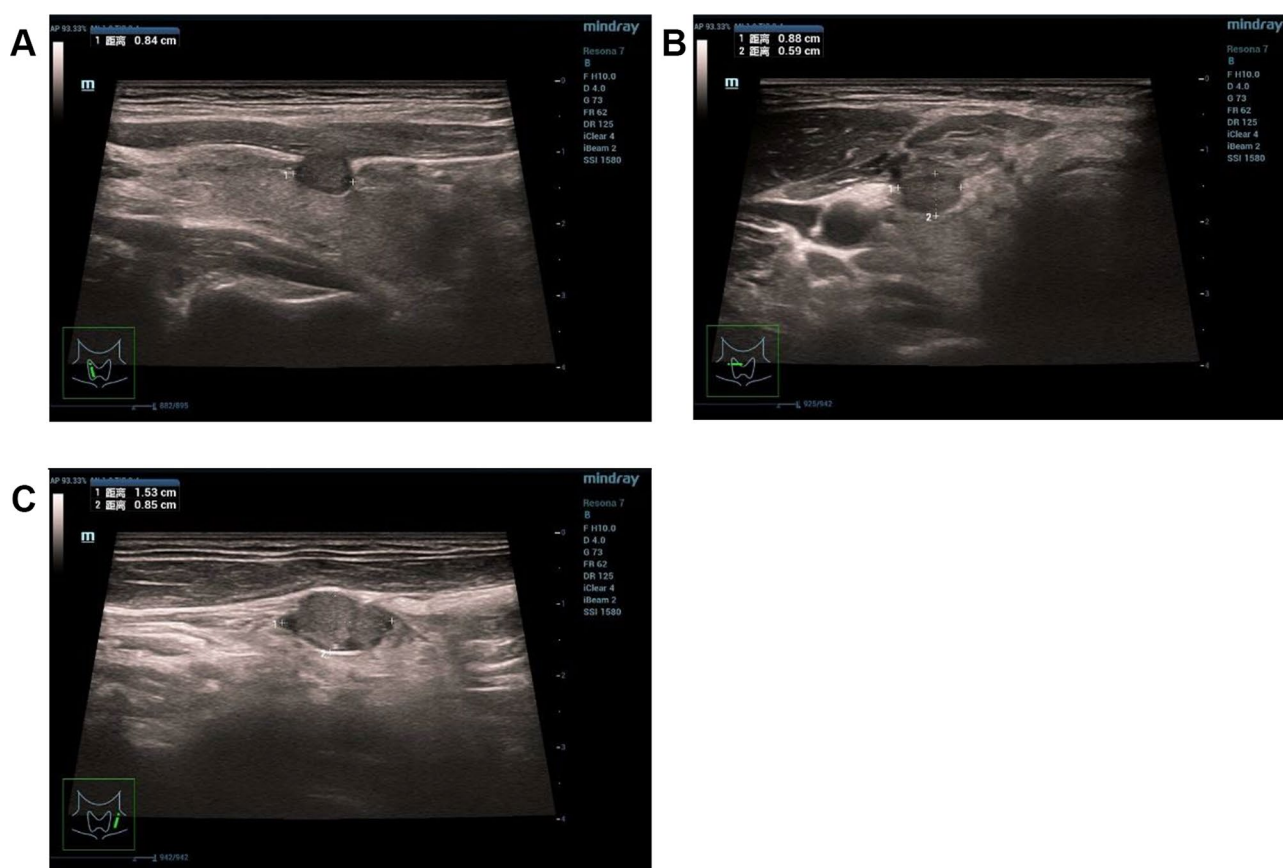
Ultrasound (US) showed hypoechoic nodular lesions in the right lobe of the thyroid gland that break through the dorsal membrane of the thyroid gland. Multiple abnormally enlarged lymph nodes may be seen in the neck
